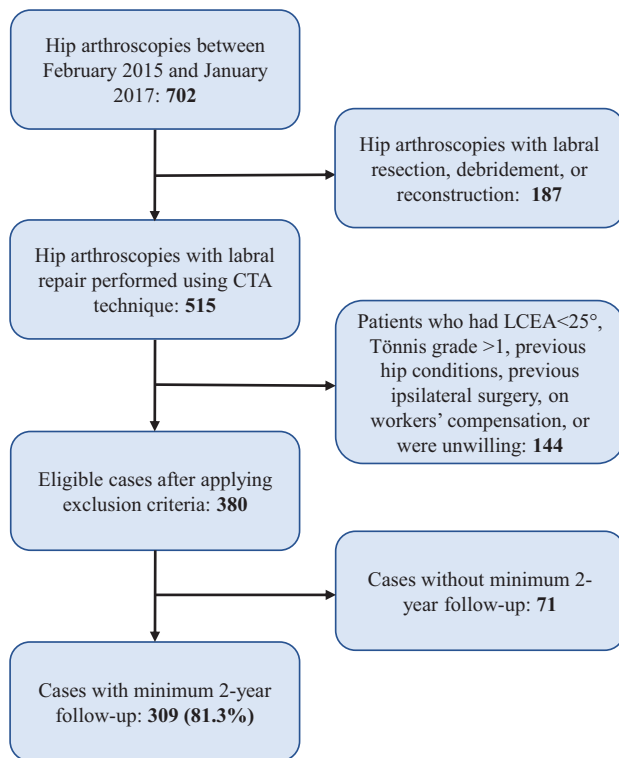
Patient selection process. CTA, computed tomography angiography; LCEA, lateral center-edge angle.
